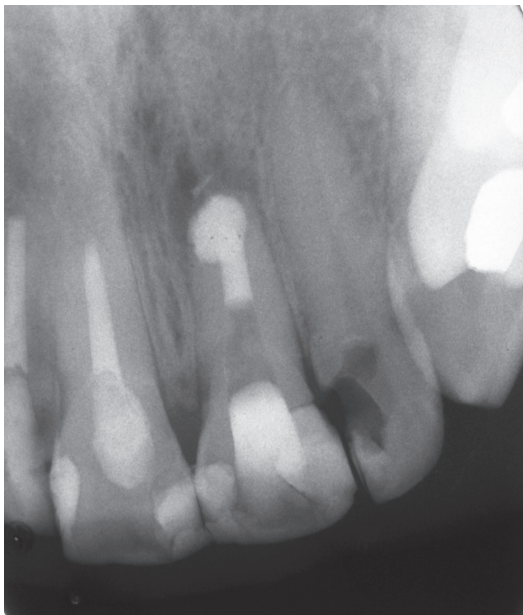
Radiograph of the apical barrier placement. An irregularly global apical part of the barrier is evident.
